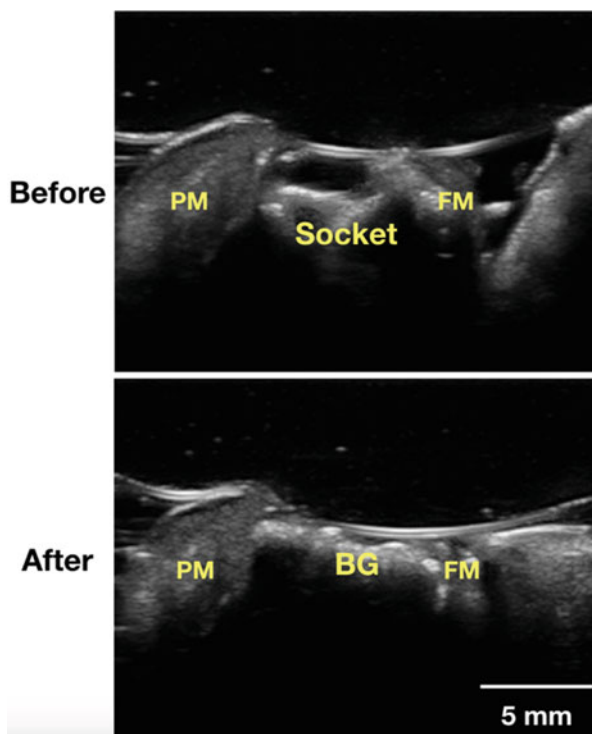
Ultrasound occlusal scan of socket augmentation before and immediately after the bone graft is Placed. *PM* palatal mucosa; *FM* facial mucosa
